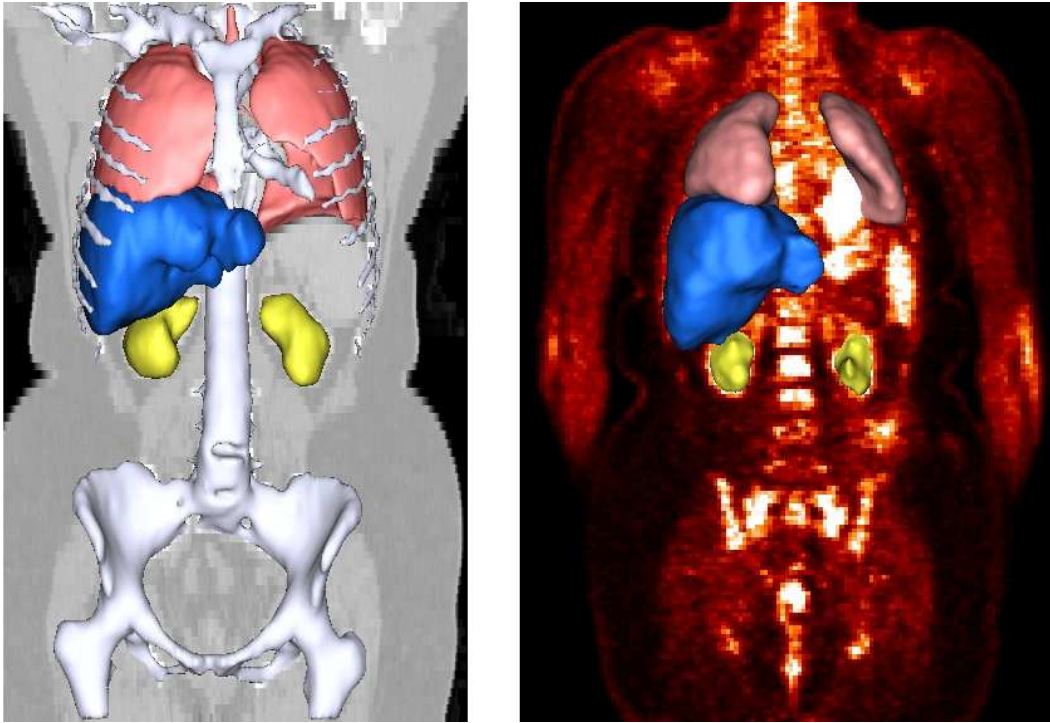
Simplex meshes of final segmented structures, including skeleton (white), lungs (red), kidneys (yellow) and liver (blue). Left: 3D rendering of CT segmented structures superimposed on a 2D coronal grey-level slice. Right: 3D rendering of PET segmented structures superimposed on a 2D coronal grey-level slice.
